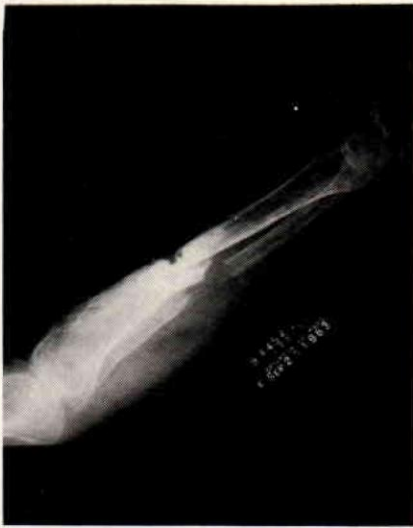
Lateral x-ray view of tibia and fibula showing non-union after multiple operative procedures.
